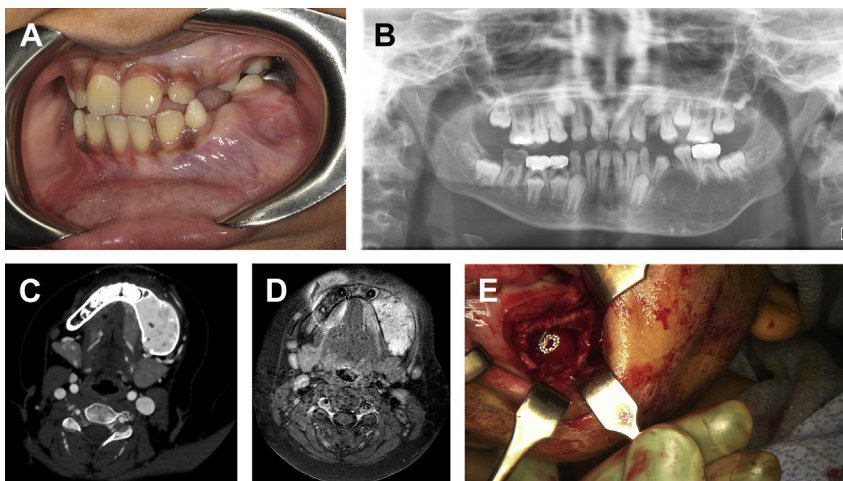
Intraoral photograph (A) of an 11-year-old male patient referred for a vestibular mass of the left mandible. The panoramic radiograph (B) shows a poorly defined expansile multilocular lesion with displacement of teeth. Computed tomography angiography (C) and MRI (D) confirmed the suspected diagnosis of intraosseous hemangioma. The lesion was successfully embolized and enucleated (E) without complications or recurrence.
